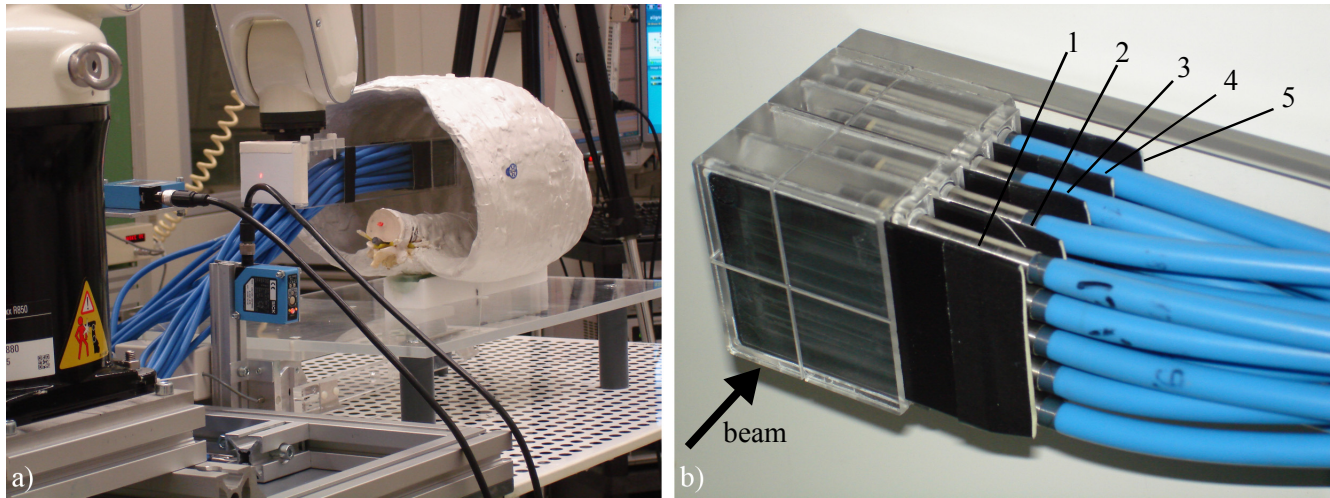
Pictures of the detector head. (a) The detector head is shown in irradiation position within the artificial thorax. (b) Picture of the fully equipped detector head. 4 rows of pinpoint ionization chambers with 5 chambers per row are used for 3D dosimetry within the target volume. In between the rows, in front of the first and behind the last row light-proof film cases are placed (black plates) covering radiographic films.
